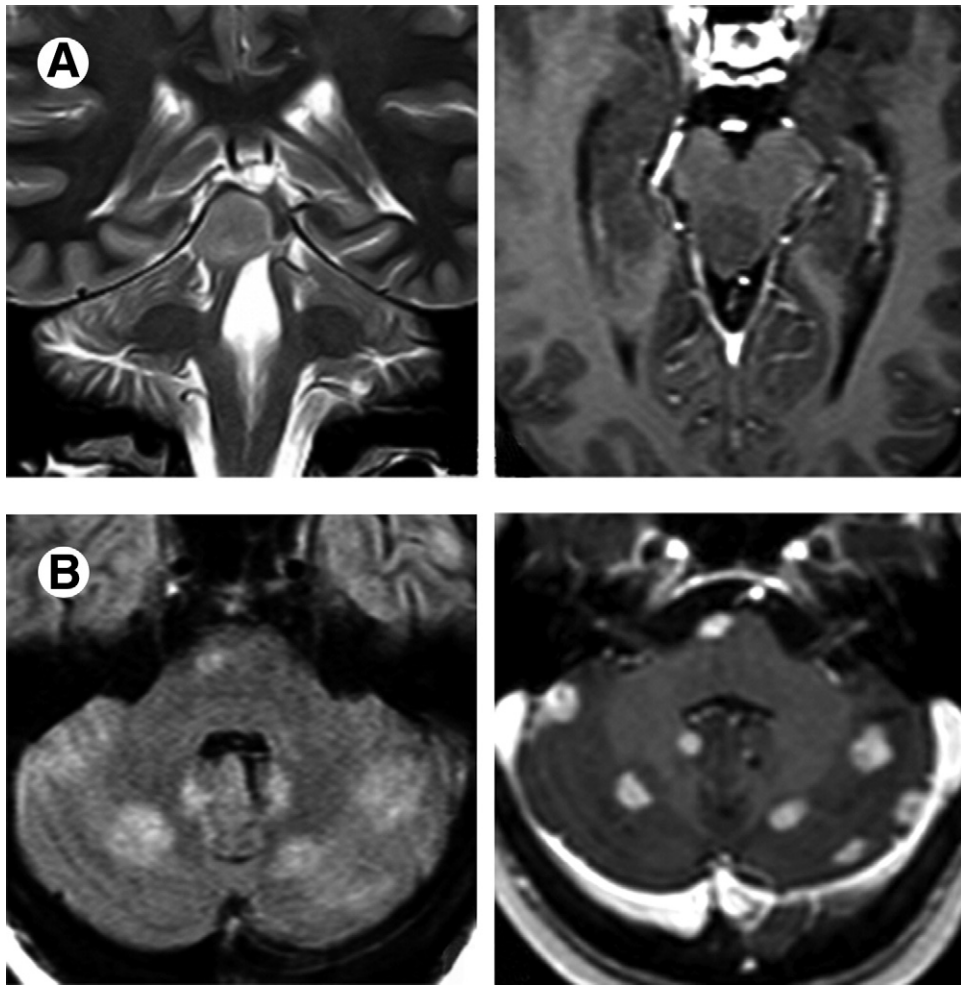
(A) Tectal glioma. Coronal T2-weighted image (left) shows a well-circumscribed, slightly hyperintense mesencephalic tectal and tegmental mass. Axial gadolinium T1-weighted image (right) demonstrates expansion into the mesencephalic tegmentum on the right side by a sharply delineated hypointense mass. No enhancement is present. (B) Multiple metastases (breast adenocarcinoma). Axial FLAIR (left) shows pontine hyperintense round focal lesion without edema. Multiple similar lesions can be seen at gray-white matter junction in both cerebellar hemispheres. Axial gadolinium T1-weighted image (right) shows ring-enhancing lesions.
